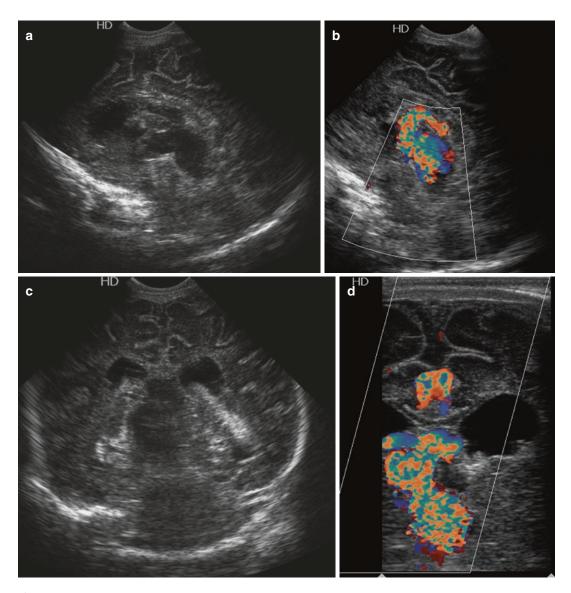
Vein of Galen malformation. (a) Grey scale and (b) colour Doppler sagittal and coronal (c and d) ultrasound images demonstrate a hypoechoic structure in the midline which demonstrates marked colour flow. Noncontrast axial CT brain (e) demonstrates the highly attenuating markedly dilated vessel and prominent venous sinuses. Single sagittal image from a cerebral angiogram (\mathbf{f}) demonstrates early filling of the vein of Galen which is dilated, as are the draining falciform, sagittal and straight sinuses. Post procedure radiograph (\mathbf{g}) demonstrates the embolisation coils in situ
